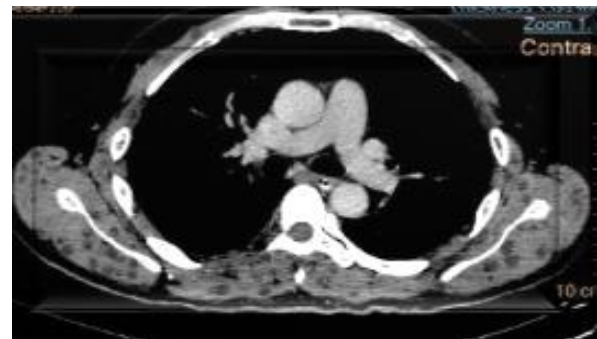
CT chest showing multiple muscular cysticerci.
